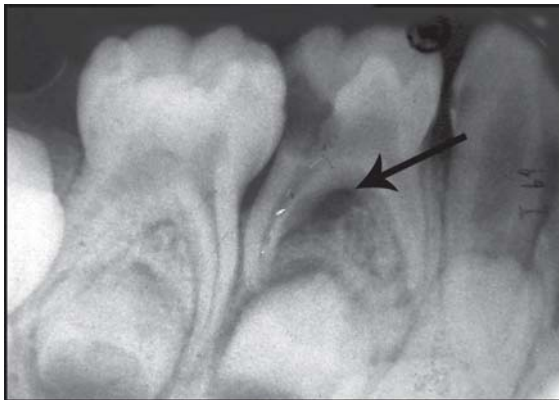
Bone resorption in the deciduous molar is observed at the furcation whereas in permanent molars radiolucency is seen at the periapical region
